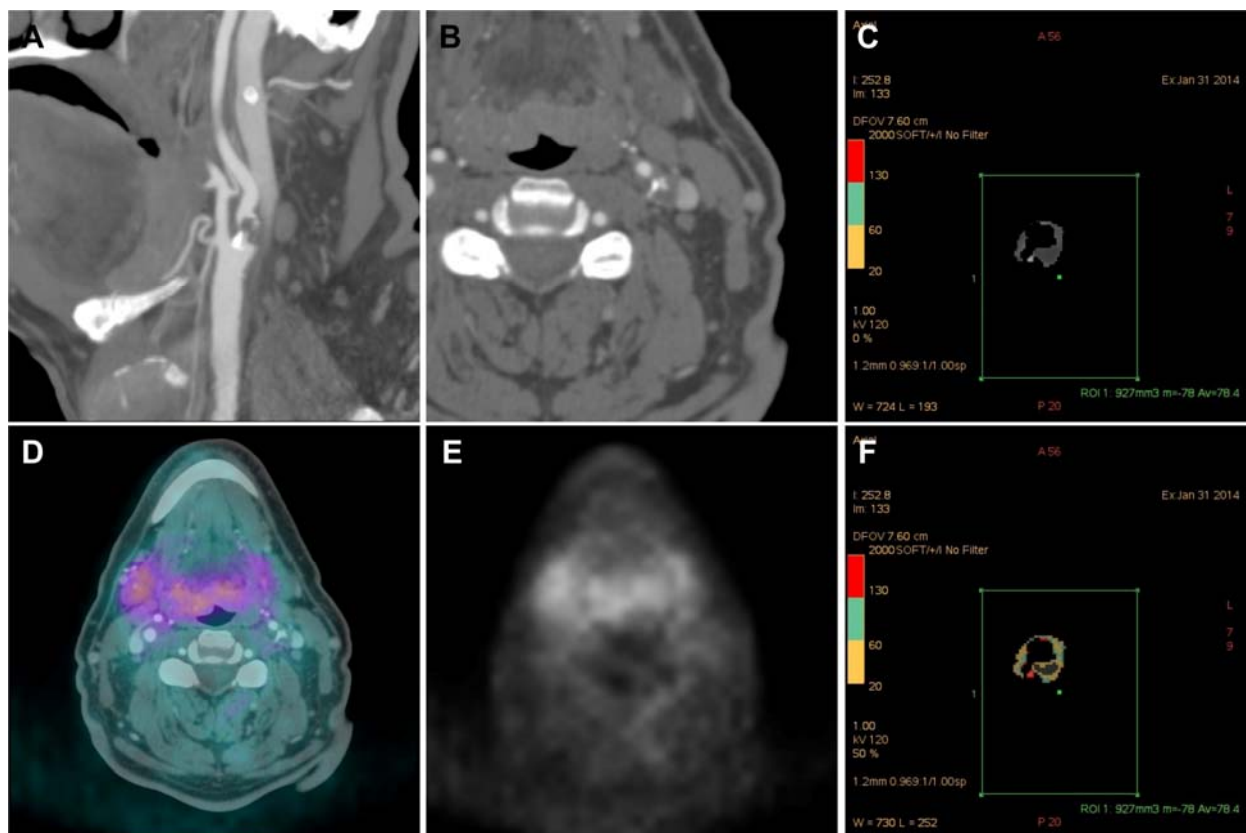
Images from a 68-year-old male with multiple recent left amaurosis fugax. A,B: CTA shows severe stenosis of the left internal carotid artery extending from the bifurcation; D,E: fused and PET image at this level; C,F: segmented plaque on CTA from a different level, with colour coded scale showing plaque compositions.
